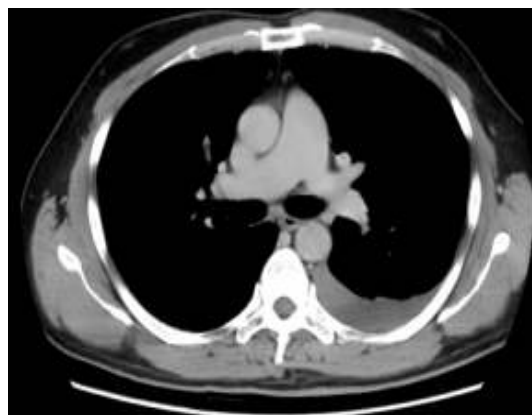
Computed tomograph Chest confirming left pleural effusion.
